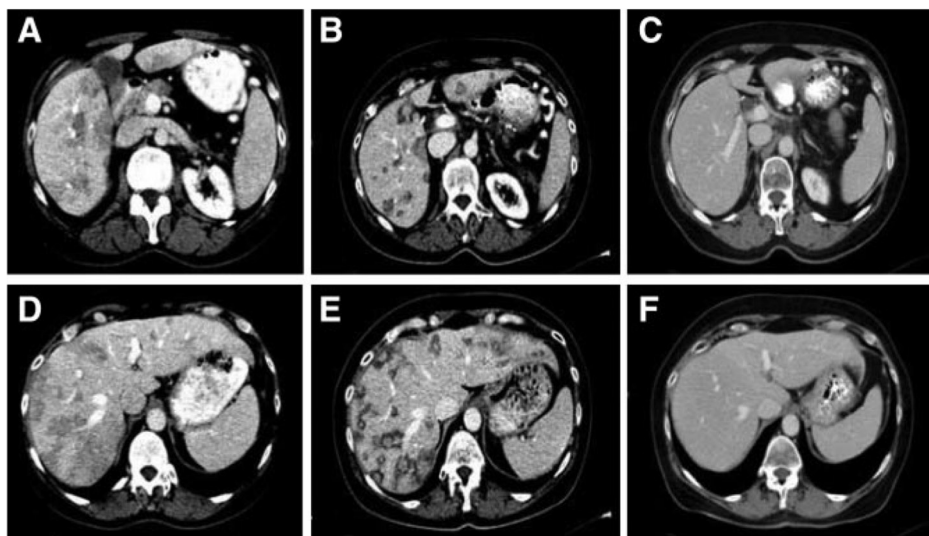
Comparison of baseline (A and D) CT scans of the abdomen and CT scans after surgery (B and E) and CT scans performed 15 months after initial diagnosis (C and F) in a 55-yr-old female with a malignant insulinoma treated with [^{177}Lu]octreotate showing remission of the liver metastases (case 3).
